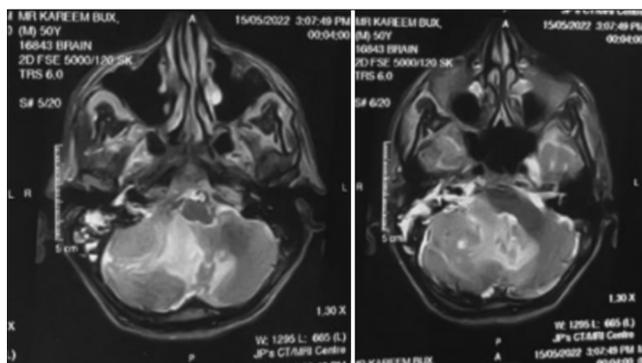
Magnetic resonance imaging brain T2-weighted sequences.
